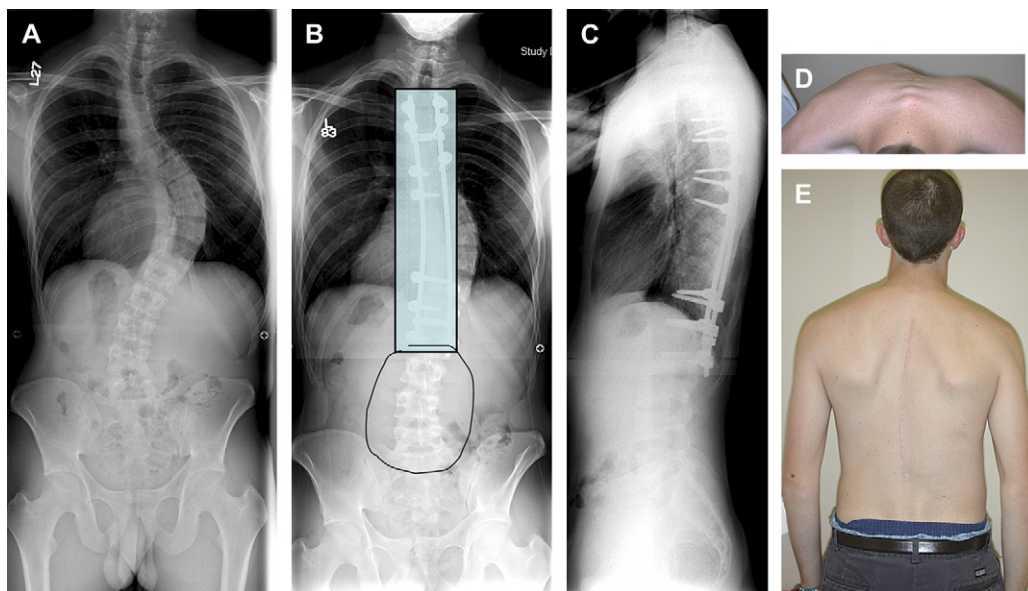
Evaluation of postoperative result at 3 years of follow-up. (A) Standing radiograph of a 16-year-old boy. (B) Standing radiograph of the patient with the instrumented part of the spine concealed to bring focus to the noninstrumented part that is straight. The instrumented spine is not important any longer because it is nonfunctional. (C) Lateral radiograph shows the instrumented spine. (D) Clinical photograph shows residual rib prominence in the patient. (E) Clinical photograph shows a posterior view of the patient at 3 years of follow-up. Note that the shoulders are balanced.
